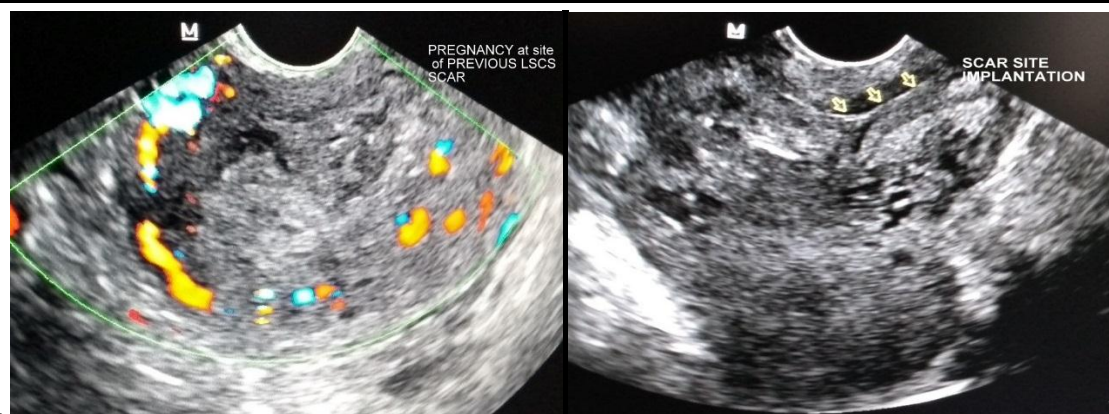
DOPPLER & USG IMAGES
